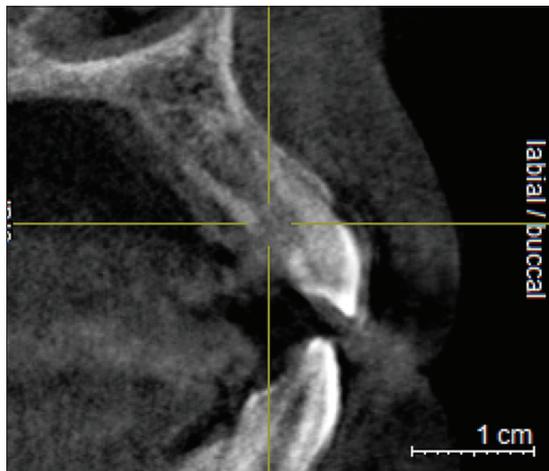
Cone beam computed tomography sagittal image showing impacted tooth
